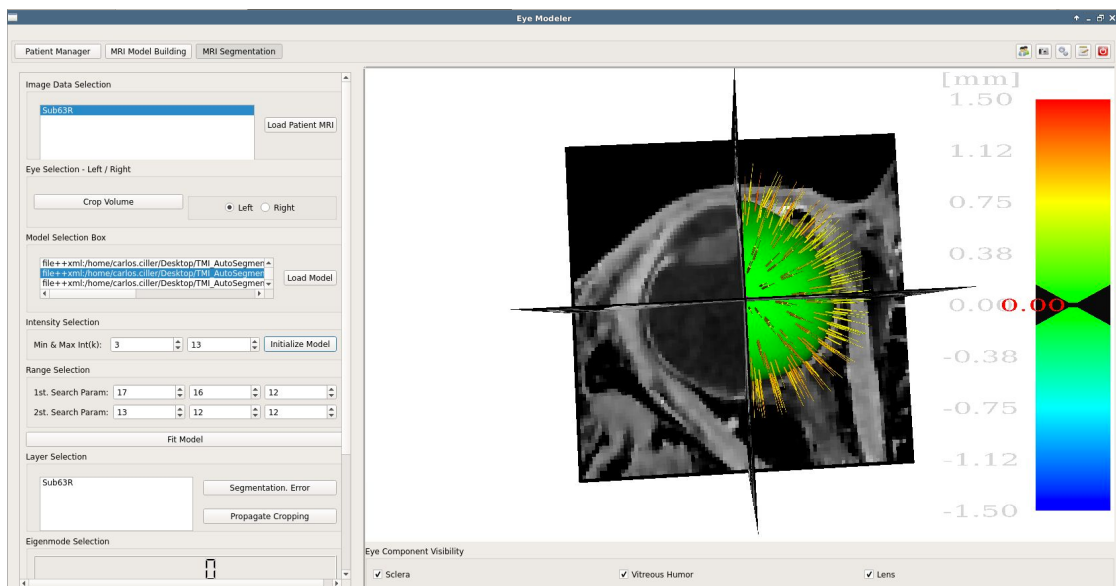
MRI Model Segmentation : In here we cover the automatic segmentation of 3D MRI. The software is ready to load volumes, crop them, select the region of the eyes and perform series of image processing steps before doing the automatic segmentation. The whole process takes on average 14s [2]. The green shape represents the model shape in NCS.
